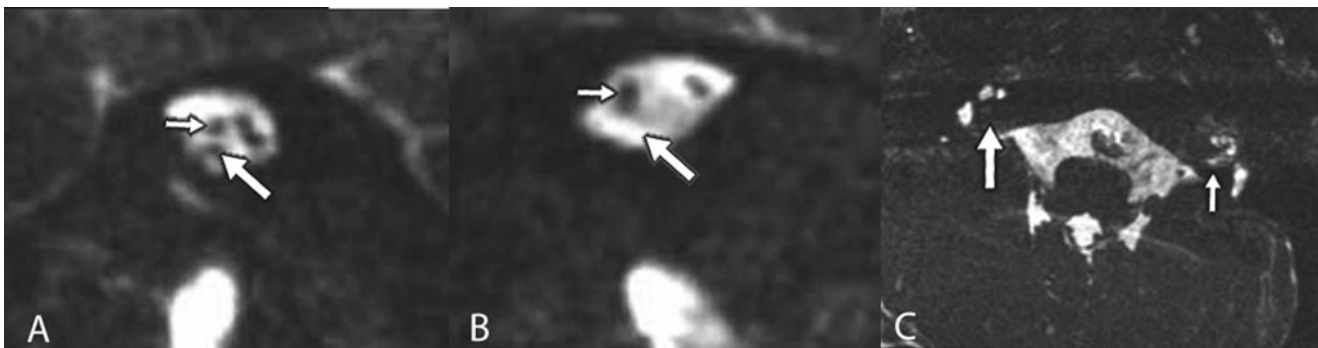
Magnetic resonance imaging of cochlea and internal auditory canal (IAC). (a) Sagittal section demonstrating normal appearance of four nerve bundles within the lateral aspect of the IAC, including the cochlear (large arrow) and facial nerve (small arrow). (b) Sagittal section demonstrating normal caliber IAC, facial nerve (small arrow), and absent cochlear nerve (large arrow points to expected position of cochlear nerve). (c) Axial section demonstrating absent right IAC (large arrow) and narrow left IAC (small arrow)
